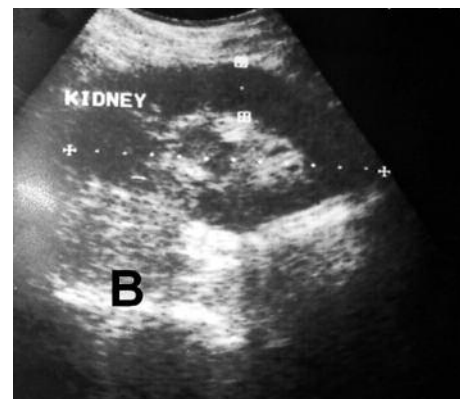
Normal renal allograft ultrasound 15 months following successful antibiotic therapy.
